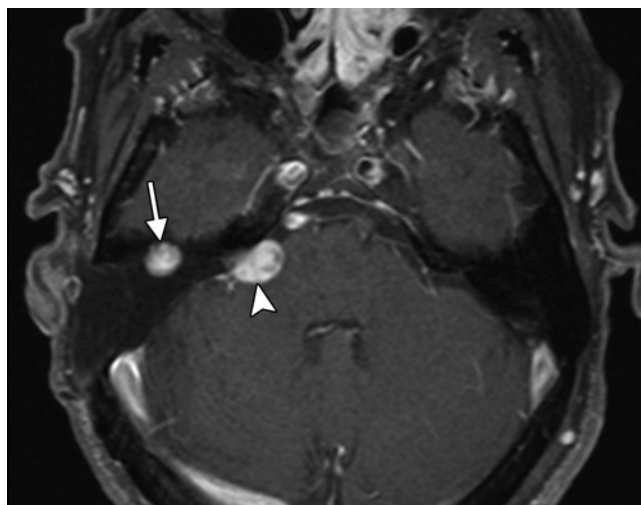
Intraoperative tumor seeding. Axial postcontrast fat-suppressed T1-weighted MRI study showing a progressively enlarging enhancing nodule anterior to the fat graft (arrow), which was not present preoperatively. Recurrent tumor is present in the right cerebellopontine angle (arrowhead).
